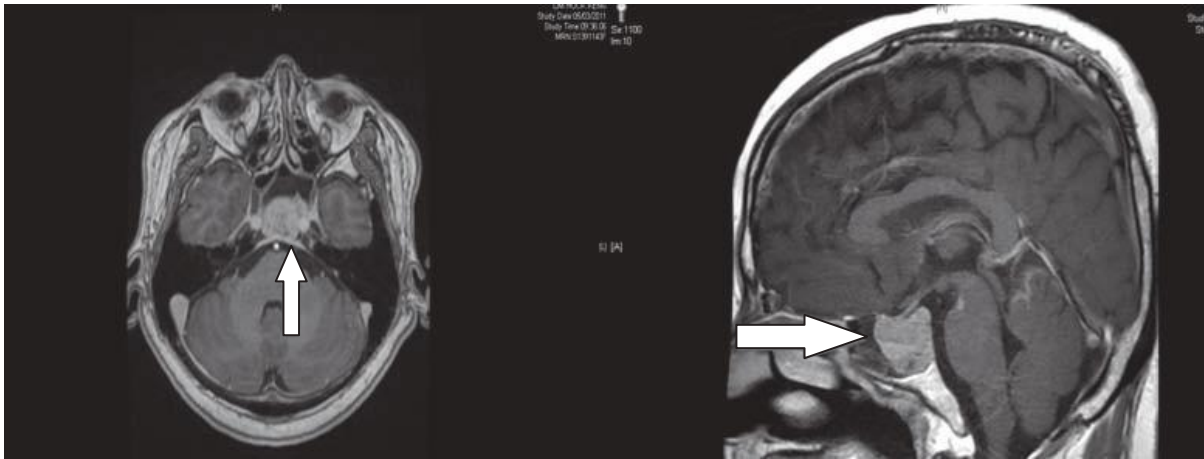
MRI Head with contrast shows the pituitary mass abutting both cavernous internal carotid arteries
